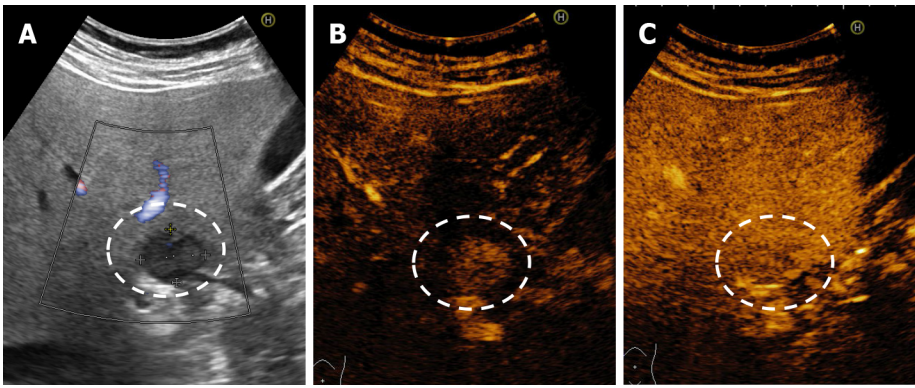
Example of a flashfilling hemangioma. A: On B-mode ultrasound a hypoechoic hemangioma is observed anterior of hepatic hilum; B and C: After injection of contrast agent, a rapid, uniform and intense homogeneous enhancement in the arterial phase (B) that persists into the late phases (C) is observed.
